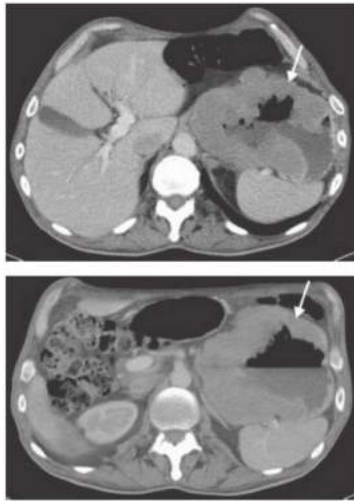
• Cross-sectional imaging with CT or MRI evaluates for distant metastatic disease and bulky adenopathy. Abdominal CT scan in a patient with known high-grade neuroendocrine tumor. No liver metastases were noted. Note diffuse nodular heterogeneous thickening of the stomach (*white arrow*).
